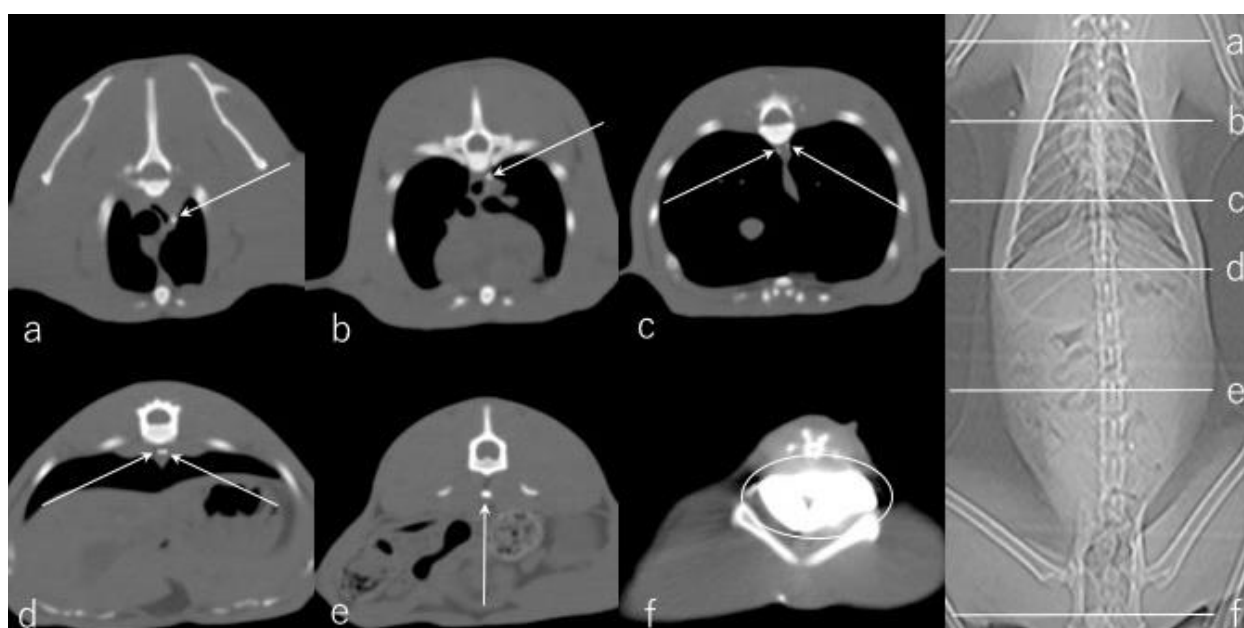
Transverse CT lymphographic images obtained five min after administration of iohexol (300 mg I/ml, 1.8 ml/kg). The subcutaneous injection site is shown with a circle in Figure 1f. The abdominal lymphatic vessels leading to the thoracic duct are depicted (arrows)
